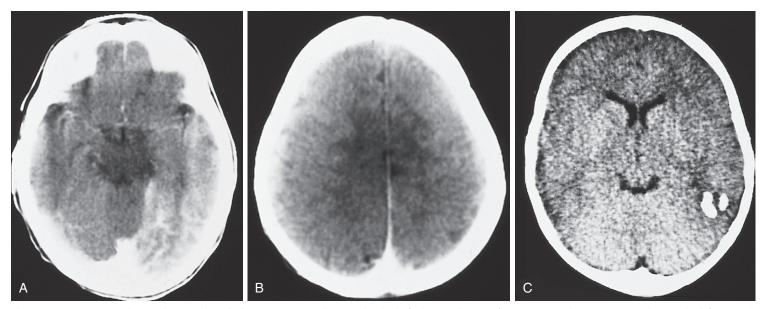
Sturge-Weber syndrome. Although the CT scan is usually normal at birth, findings such as gyriform contrast enhancement, seen here in the left occipital, temporal, and parietal lobes (A), and associated hemispheric atrophy (B) may be observed as early as 4 months of age. Serpiginous parenchymal calcifications may be found in the older child (C). (Courtesy Division of Neuroradiology, University Health Center of Pittsburgh, Pitsburgh, Pa.)
